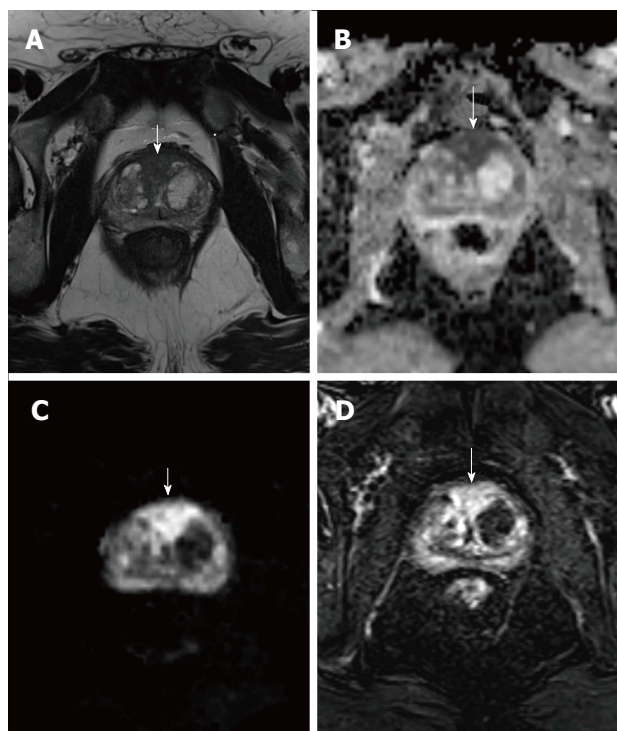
A 71-year-old patient. A: T2-weighted axial image at the level of the midgland of the prostate shows a hypointense nodular lesion at the transitional zone/anterior fibromuscular stroma, with a diameter of 26 mm (arrow); B and C: ADC map (B) and DWI image (C) show a marked hypo- and hyperintensity, respectively, in relation to restriction of diffusion (white arrows); D: DCE image with significant enhancement of the lesion (arrow). The characteristics of the nodule are compatible with a PIRADS 5 lesion and the marked restriction of the diffusion suggests a high-grade clinically significant prostate carcinoma, confirmed by the results of a MRI-guided transrectal ultrasound prostate biopsy (Gleason 4 + 4).
